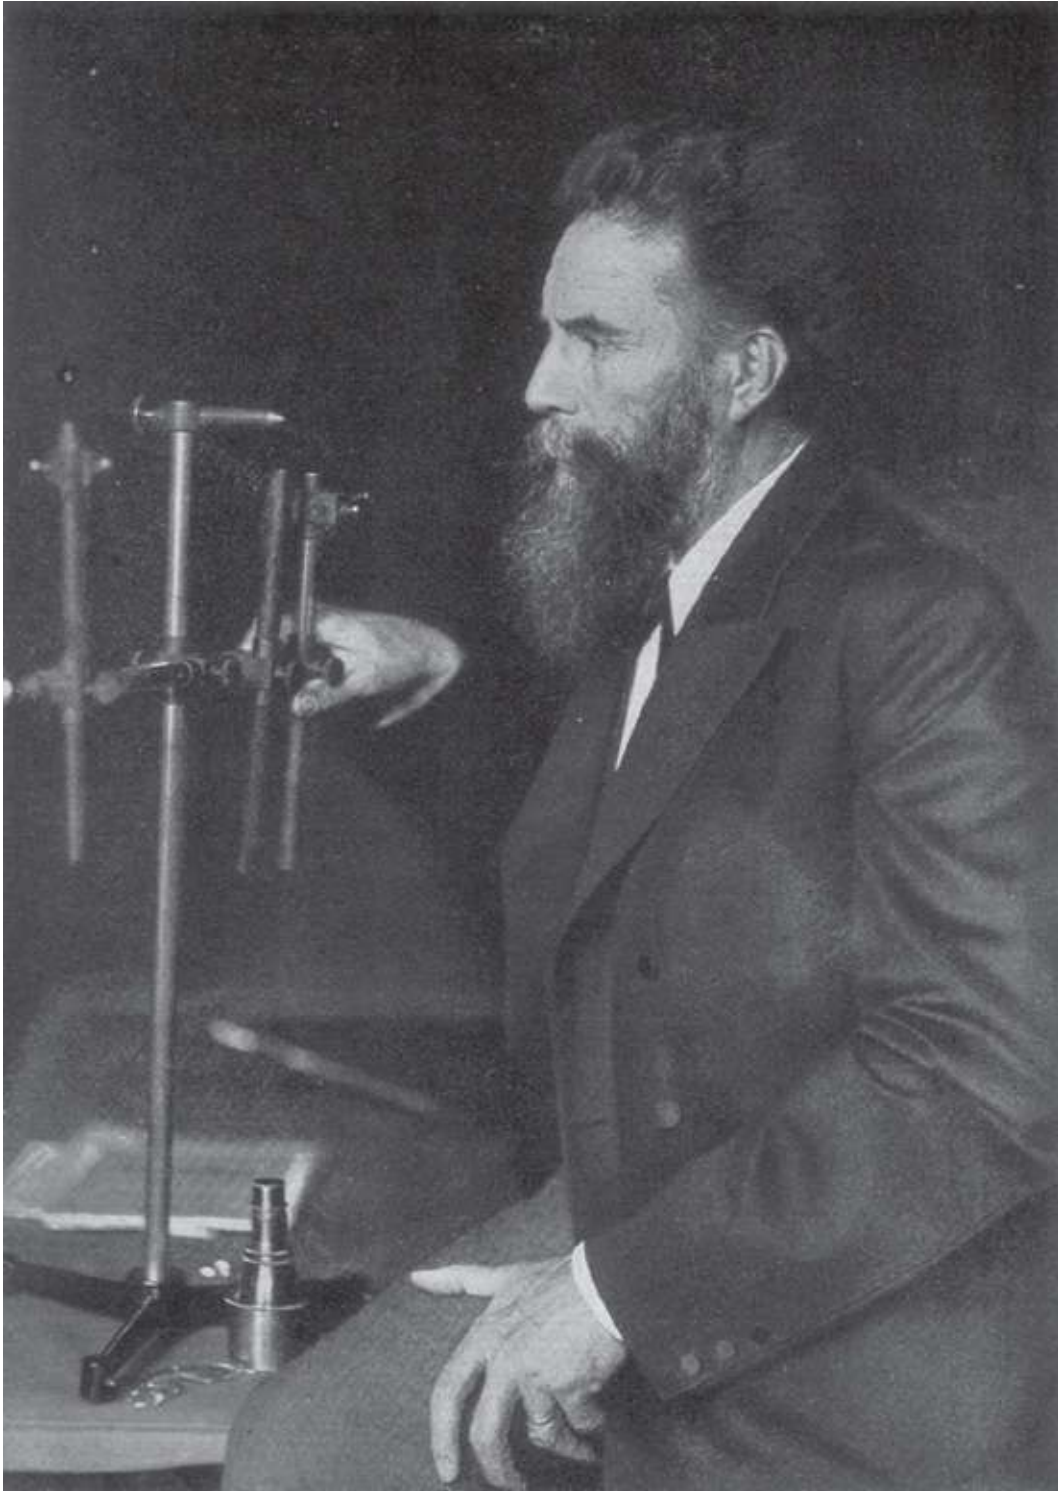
Wilhelm Conrad von Röntgen. He is shown in this photograph with physics instruments. (From Glasser O. *Wilhelm Conrad Röntgen and the early history of the Roentgen rays*. Springfield, IL: Charles C. Thomas, Publisher, Ltd., 1934, with permission.)
